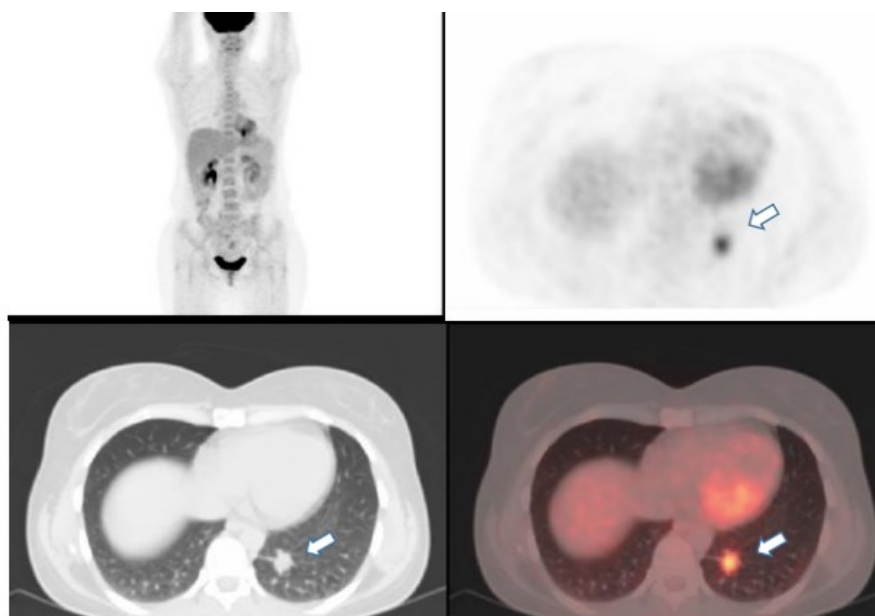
y.o female with incidental finding on chest CT, hypermetabolic LLL SPN; MIP, PET, axial CT, axial fused images; postoperative morphology revealed adenocarcinoma.
